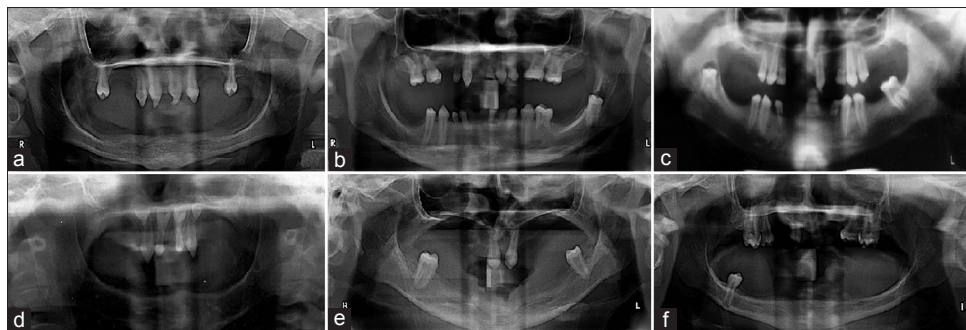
Panoramic radiographs showing partial anodontia, conical-shaped teeth and thin alveolar bone
